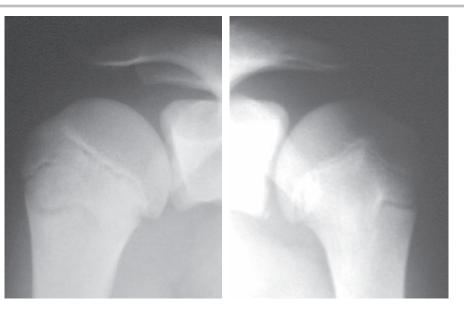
X-ray images at corrected frontal plane of the right shoulder (5) and left shoulder (6), where we observed a major reduction of the growth physis enlargement (5), compared to previous X-ray images, but still slightly enlarged when compared to contralateral side (6)
